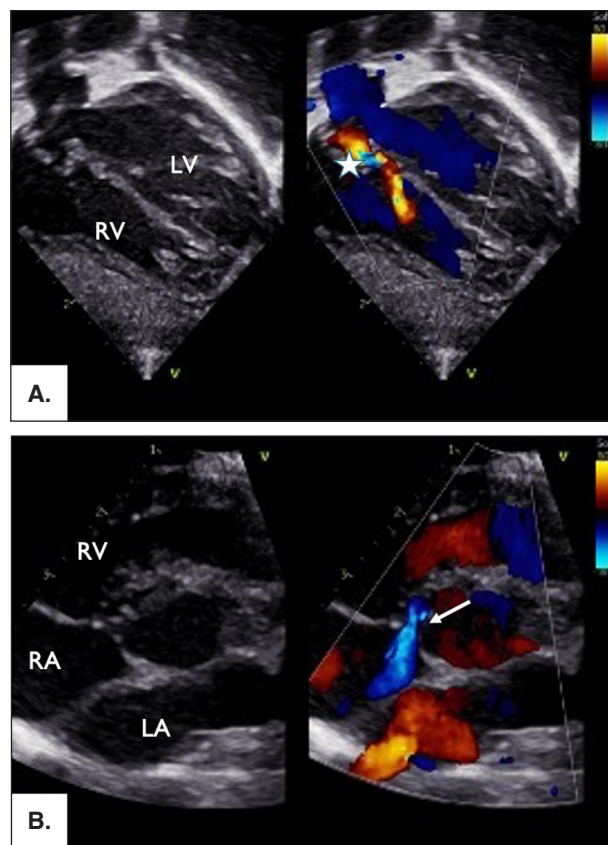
Double echocardiographic view of the same interventricular communication. A. Sub-costal long-axis view showing the interventricular defect with left-to-right shunt (red Doppler flow). B. Parasternal short-axis view showing the same defect but with the passage of blood into the right atrium (RA) in the systolic phase (blue Doppler flow). LV: left ventricle; RV: right ventricle; LA: left atrium; RA: right atrium; star: interventricular communication; arrow: LV-RA communication.
